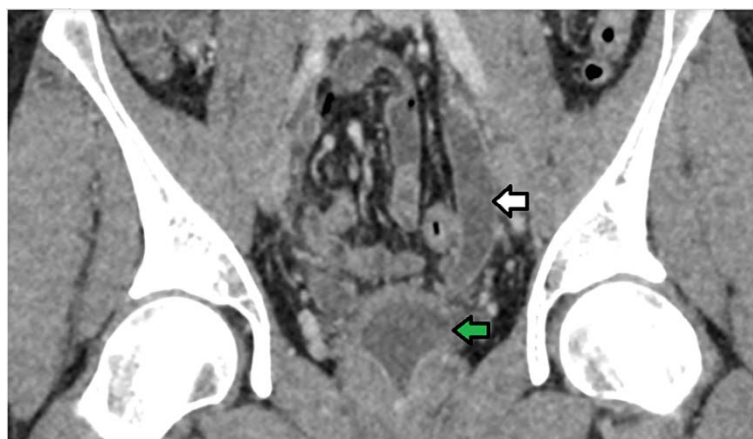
Coronal CT image of the pelvis with contrast demonstrates a thickened urinary bladder (green arrow) and dilated left ureter (white arrow)
